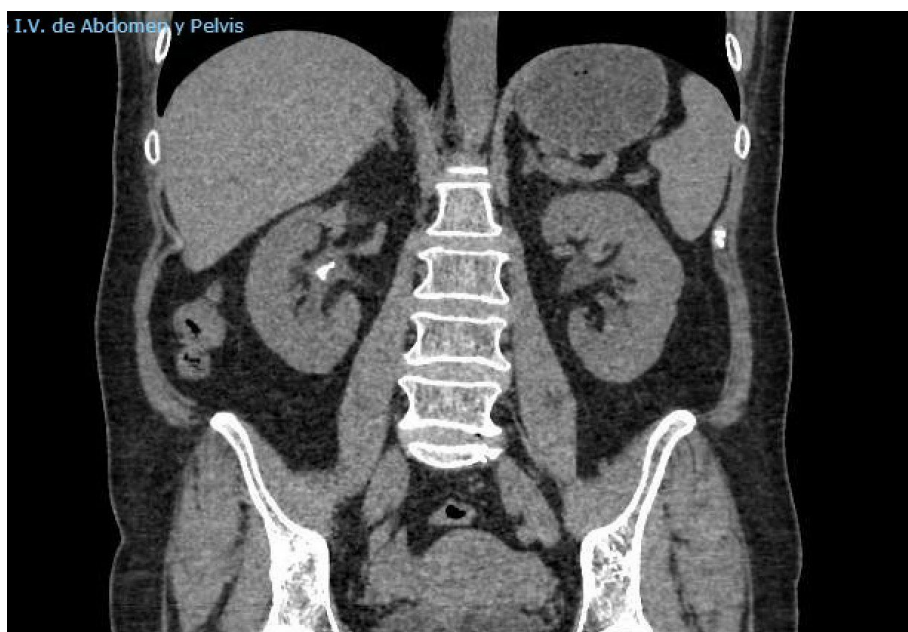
Coronal section in abdominopelvic CT after partial alkalinization.
